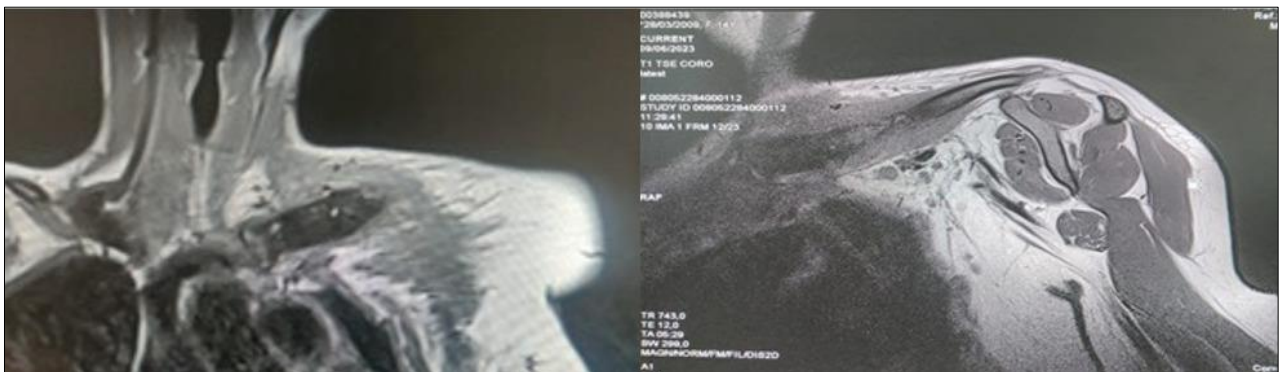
Magnetic resonance imaging showed diffuse multiple hypo-signal lesions hypertrophy of the medial third of the left clavicle
